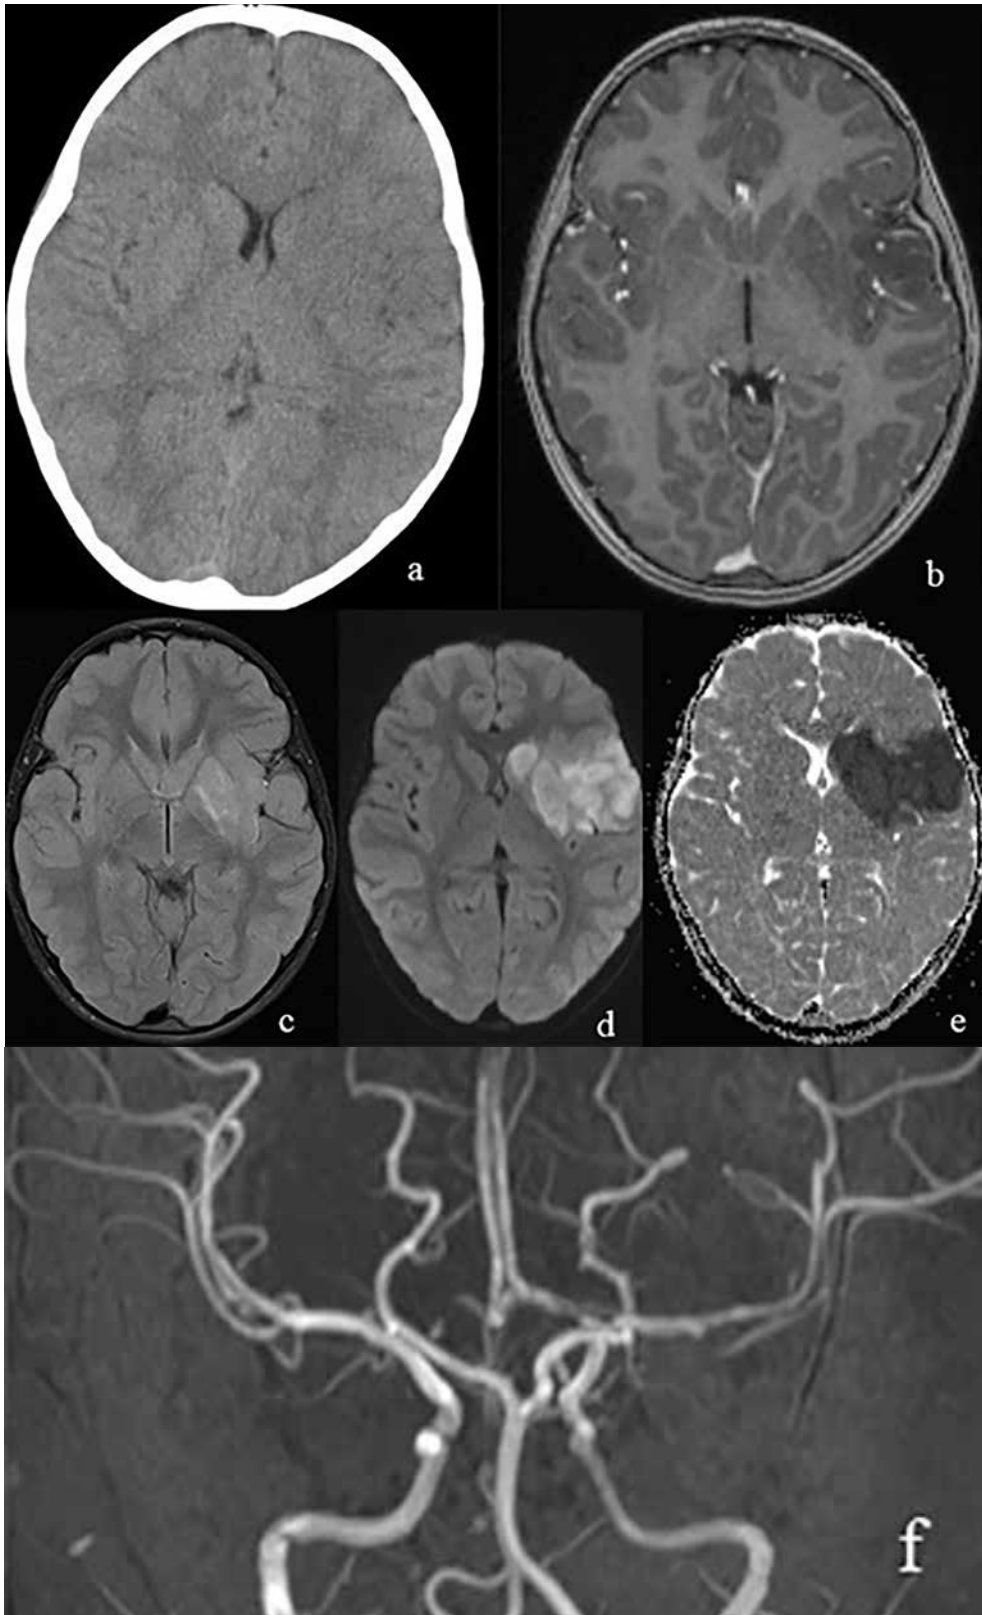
CT and MRI of an ischemic stroke in the left MCA (a - axial CT showing no features of stroke in the early stages; b-f MRI: b - T1W axial; c - T2W FLAIR axial; d - DW axial; e - ADC axial; f - TOF)
